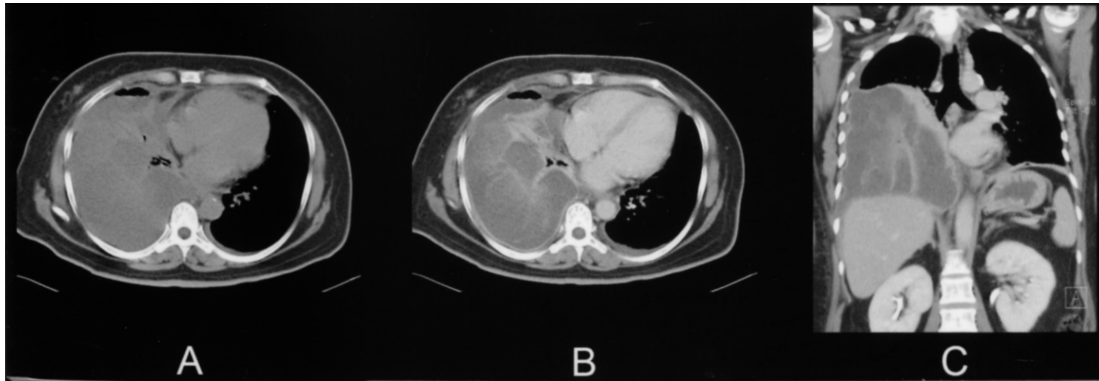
Chest computed tomography. Non contrast-enhanced axial images revealed marked right pleural effusion with heterogeneous hypodensities (Figure 2A). Contrast-enhanced axial and coronal images showed several ill-defined hyperdensities distributed irregularly within the right pleural cavity (Figure 2B, 2C).
